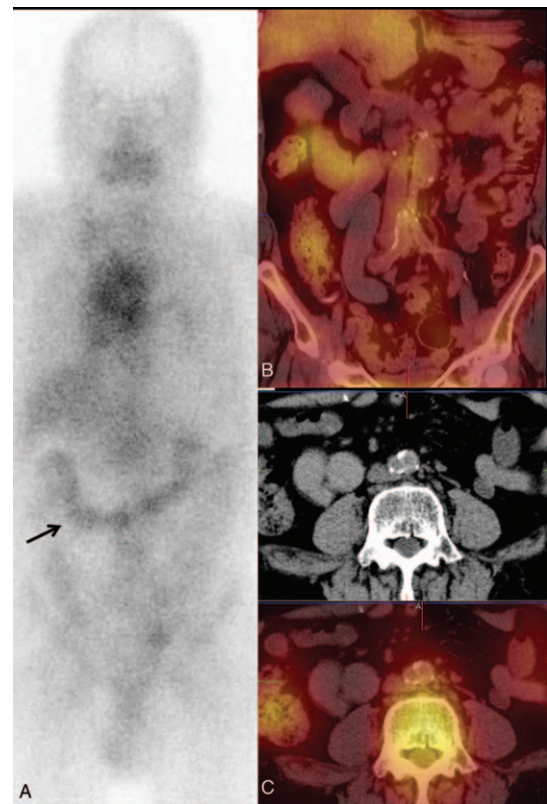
(A) ^{67}Ga planar scintigraphy showed similar ^{67}Ga uptake in the mediastinum and right lower neck seen at ^{18}F -FDG PET/CT, and there was suspicious physiologic uptake in the bowel. (B and C) Coronal and transverse fusion images of ^{67}Ga SPECT/CT revealed no definite abnormal ^{67}Ga uptake in the previous aortobiliac bypass sites with intense ^{18}F -FDG uptake seen at PET/CT imaging. ^{18}F -FDG = ^{18}F -fluorodeoxyglucose, ^{67}Ga = ^{67}Ga -citrate, PET/CT = positron emission tomography/computed tomography, SPECT/CT = single photon emission computed tomography/computed tomography.
